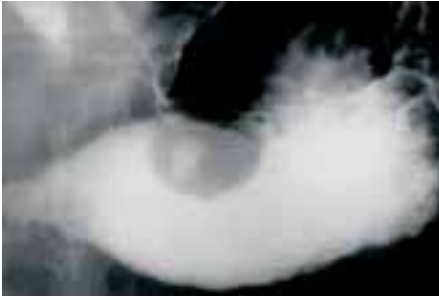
Radiograph demonstrating mass defect in stomach due to a stromal tumour.
